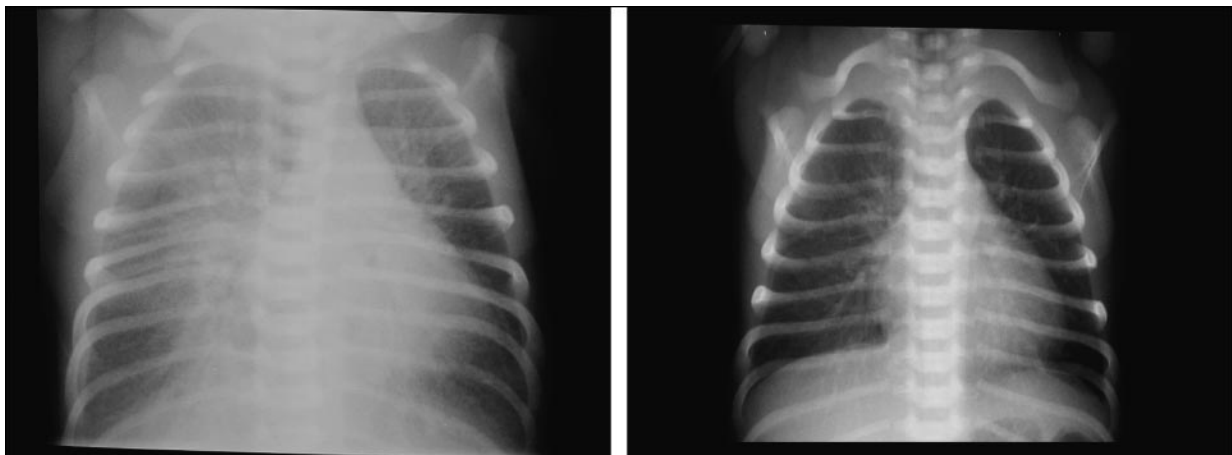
Radiographs of two babies who have transient tachypnea of the newborn of differing severity. Note the streaky lung opacities and fluid in the minor fissure on the right side.
